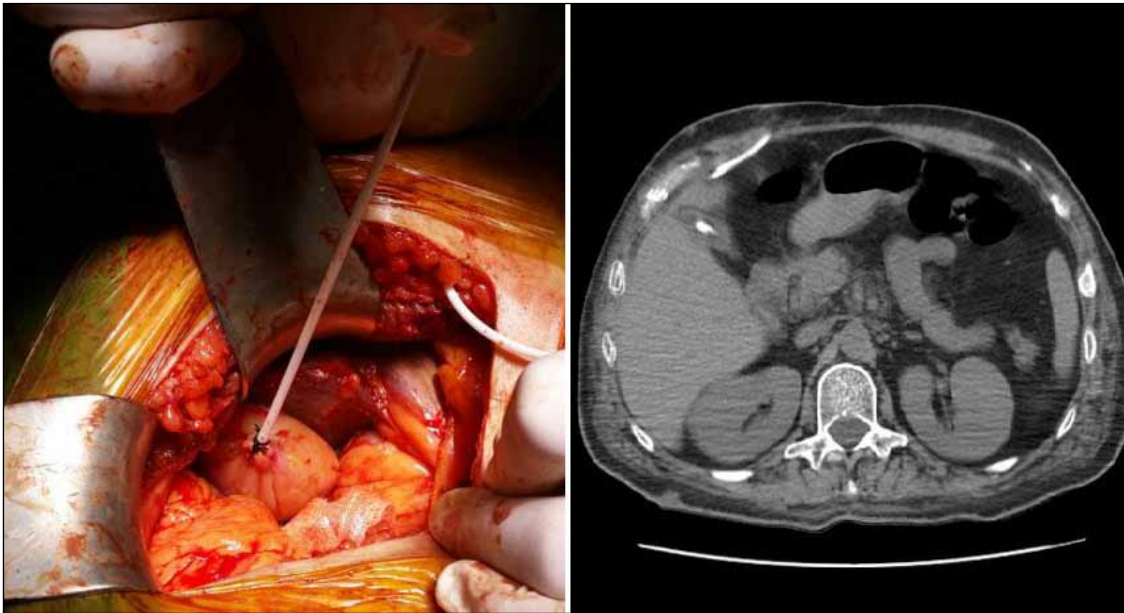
The distal end of the ventriculo-gallbladder shunt was placed inside the gallbladder (Left). Abdominal computed tomography shows the distal end of the ventriculo-gallbladder shunt in the gallbladder (Right).
